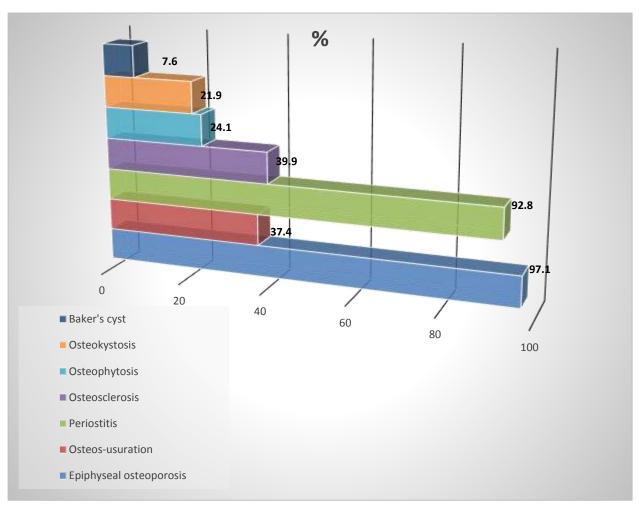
X-ray signs of the knee joint in patients with reactive arthritis.
